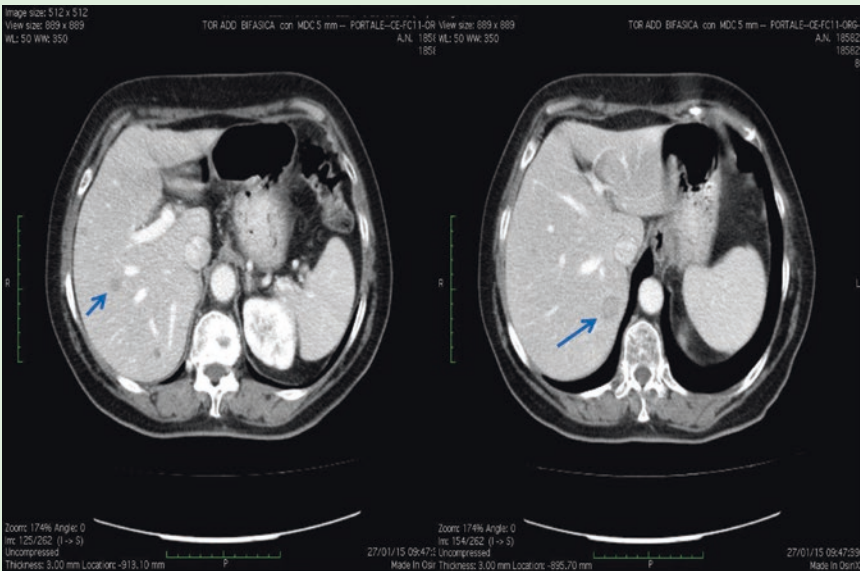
CT scan (January 2015): multiple liver metastases (blue arrows)
